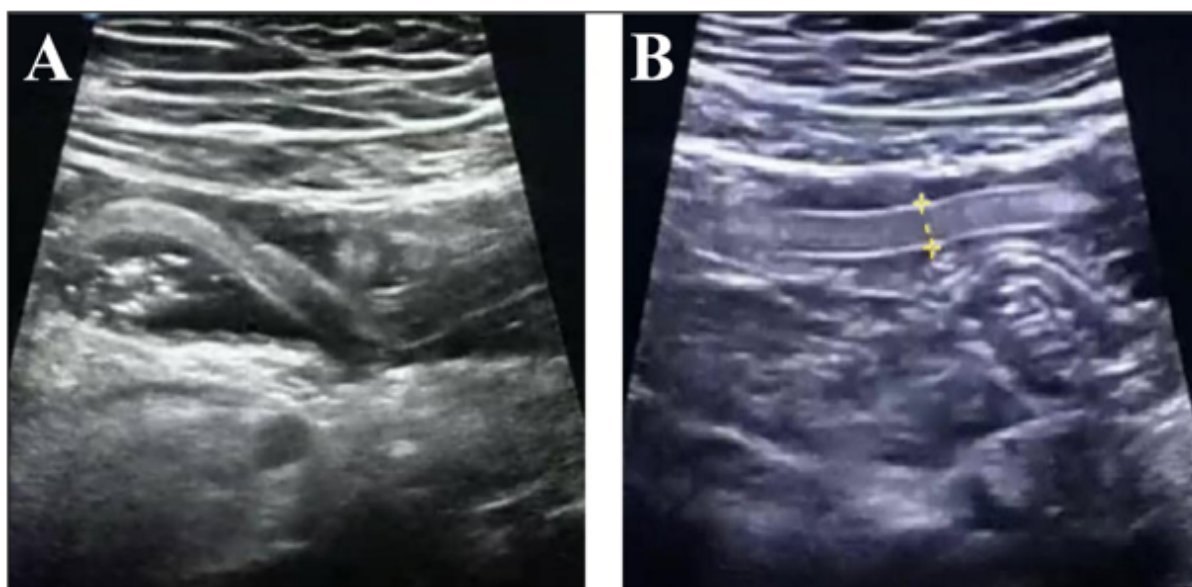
Ultrasonography of the right lower quadrant in transverse (A) and oblique transverse (B) planes. The reflection revealed a tubular hypoechoic structure with a well-defined echogenic wall within the ileal loops proximal to the appendix. This structure was consistent with that of the *Ascaris* worm.
